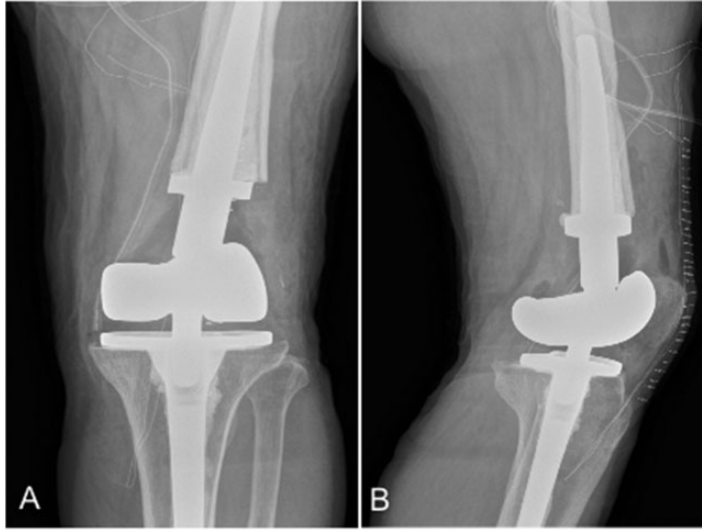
Standard anteroposterior (a) and lateral and (b) X-ray of the postoperative left knee.
